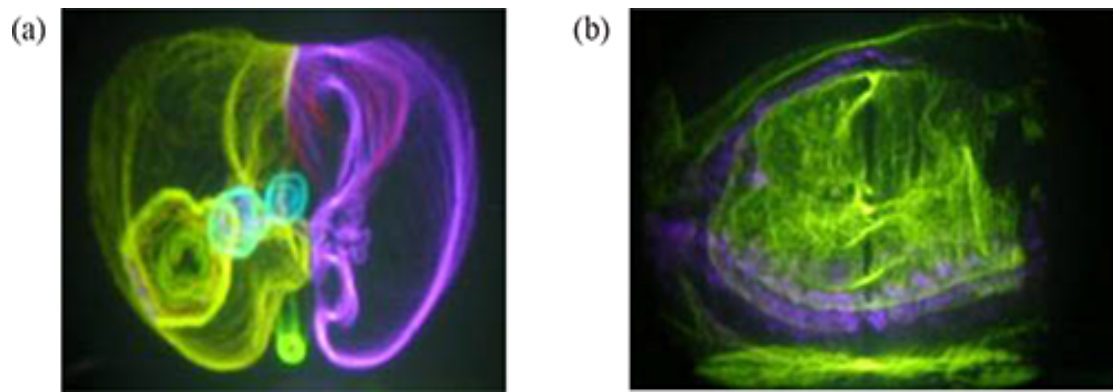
Perspecta autostereoscopic display of images transferred from Pinnacle planning system (from (Magjarevic et al., 2007)). (a) Region of interest (ROI) based image. Individual ROIs can be tagged with different colours. Right and left lungs are in green and purple respectively. Tumour is bright green in right lung. Nodal disease is in blue. (b) CT-based image. Different colours can be assigned to specific ranges of CT densities. Here purple is assigned to bone.
